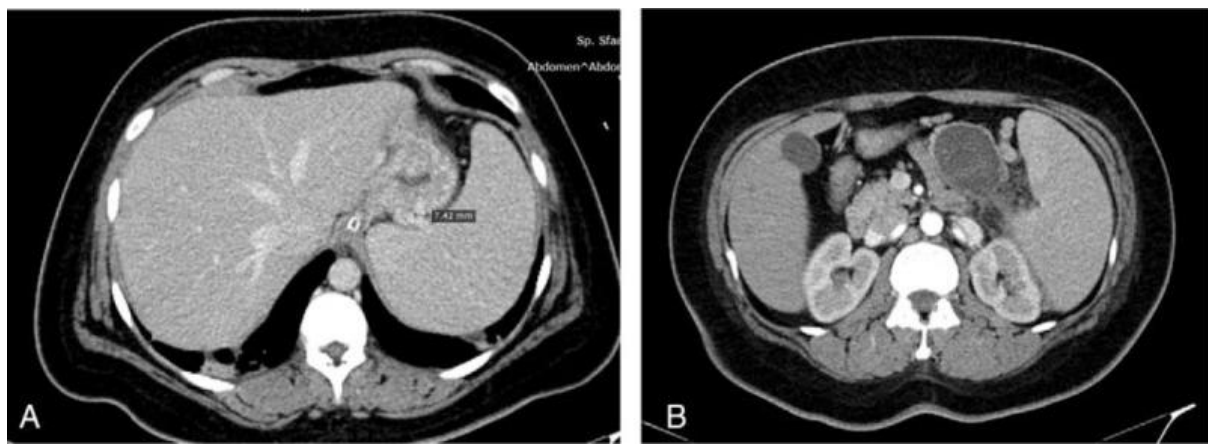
Abdominal CT. January 2015: Patent splenic vein and normal-sized spleen in a patient with incidental finding of a well defined pancreatic cystic lesion located in the tail of the pancreas (A).
